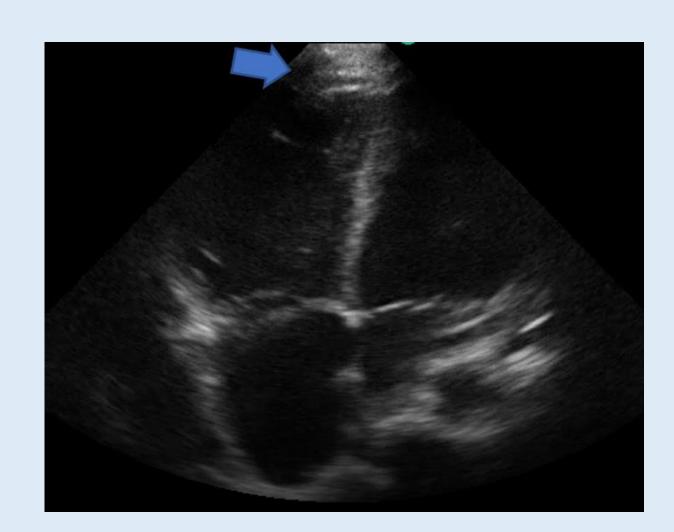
Apical four chamber view, McConnell's sign: Regional pattern of right ventricular dysfunction, with akinesia of the mid free wall and hypercontractility of the apical(blue arrow) wall
